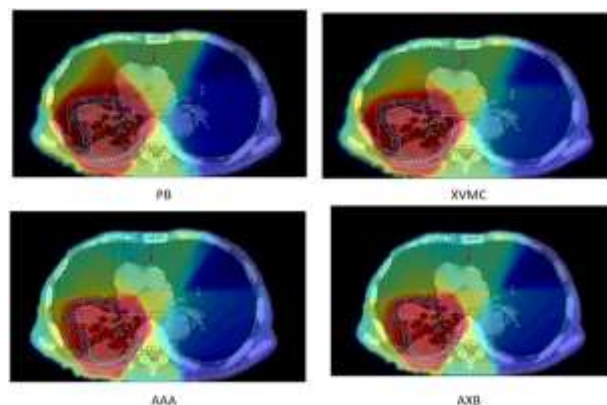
Dose distributions of different algorithms on the same CT slice.
